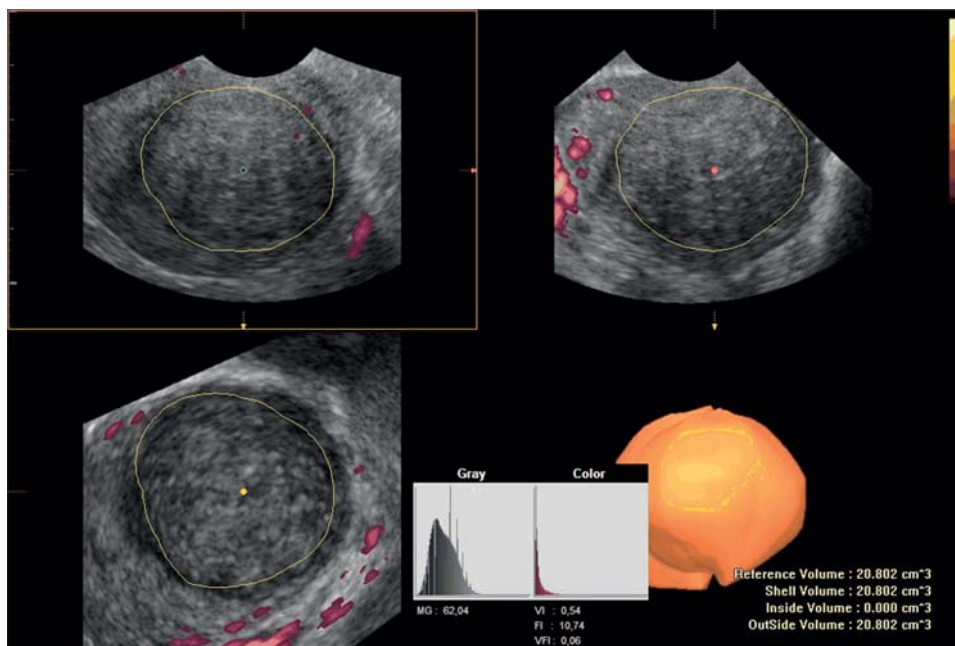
3D Power Doppler image in VOCAL: oval fibroid with vascular capsule, good peripheral penetration
